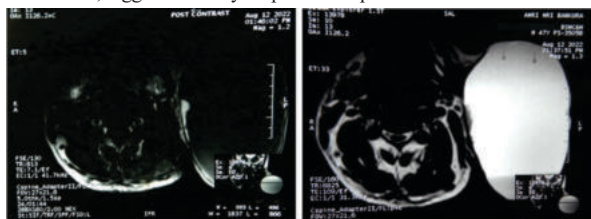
MRI T1 and T2 phase showing the neoplastic lesion
